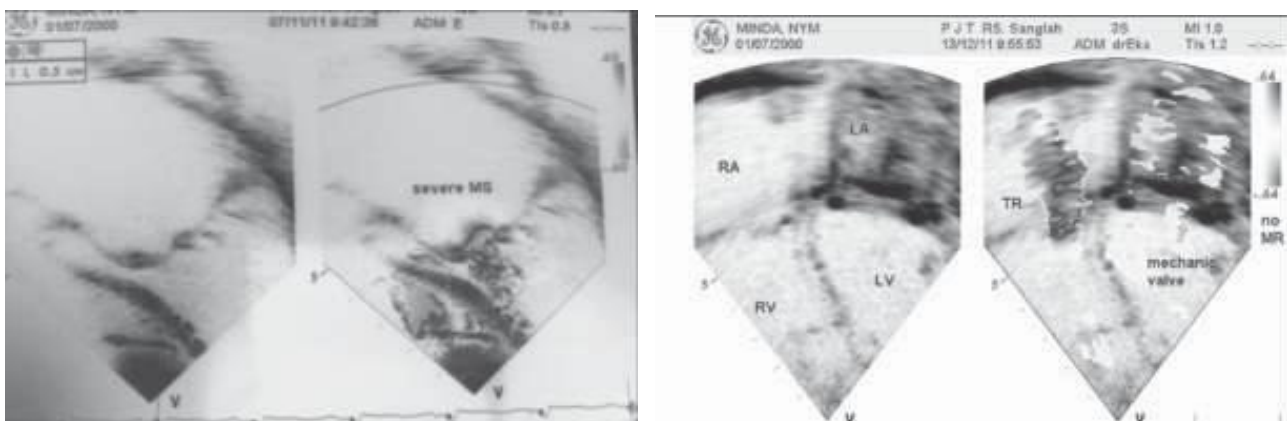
(A) Preoperative echocardiogram showing severe mitral stenosis; (B) Postoperative echocardiogram showing no mitral regurgitation.
